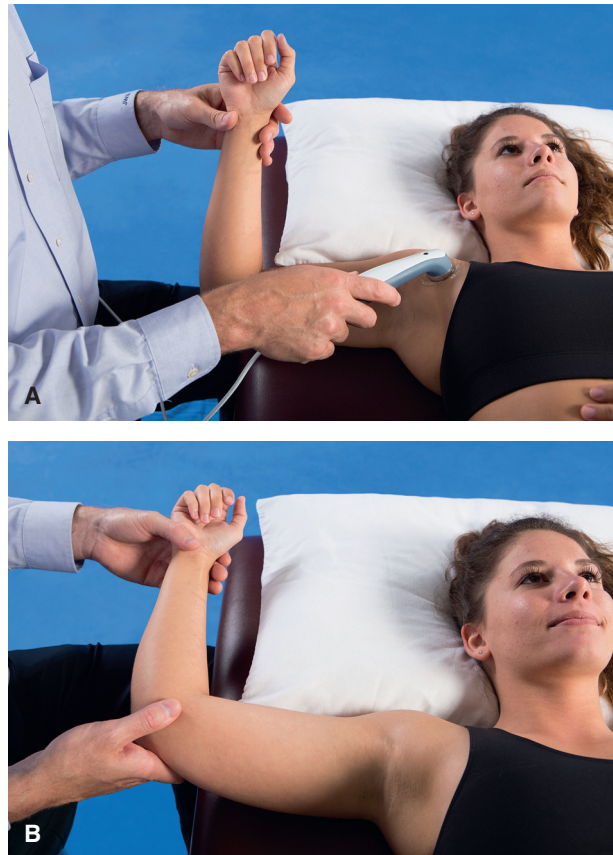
Thermal ultrasound (A) applied with the shoulder followed by (B) manual stretching into external rotation.
